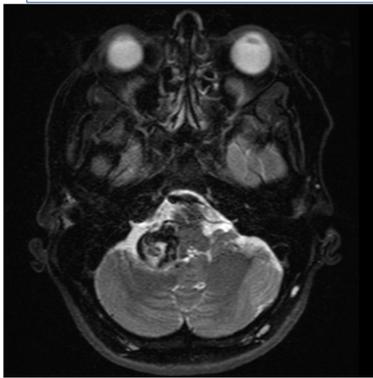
MRI T2-weighted image showing right cerebellomedullary mass
